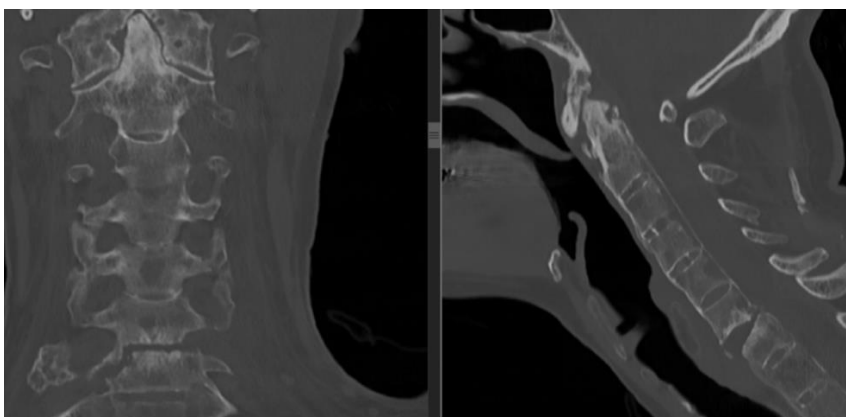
C6-C7 transdiscal fracture type C AO on CT scan
